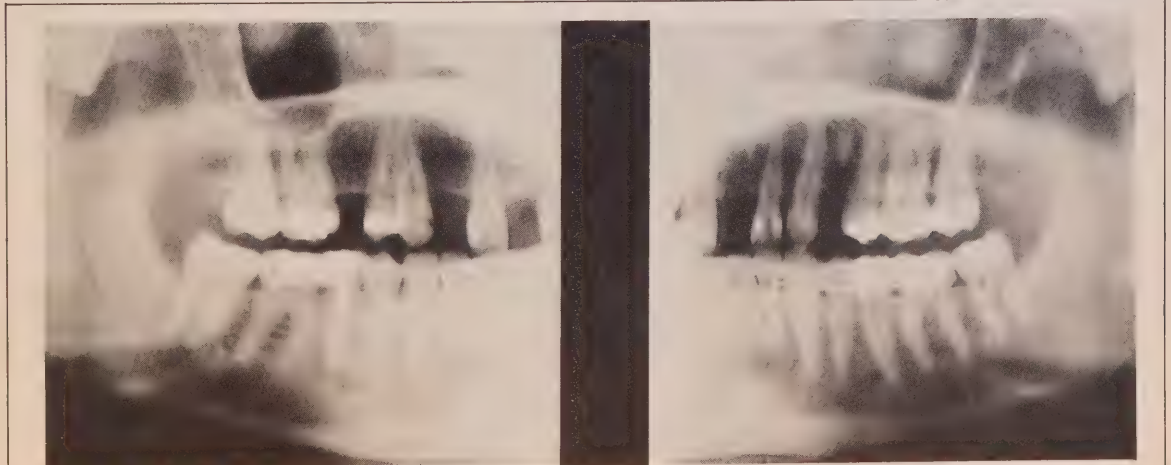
Panoramic radiograph demonstrating fracture site (arrowed).
